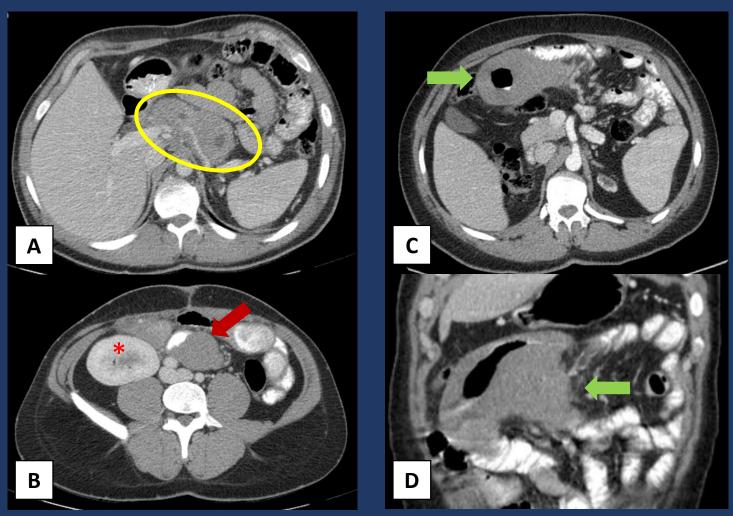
Axial (A, B) CT scan of a patient with a renal transplant shows bulky retroperitoneal adenopathies (circle) and a soft-tissue exophytic mass in an ileal loop (red arrow), which after the resection revealed to be a lymphoma. Note the transplanted kidney in the right iliac fossa (asterisk). In a two-years follow-up axial (C) and coronal (D) CT scan, the patient had recurrence of the lymphoma (green arrow).
